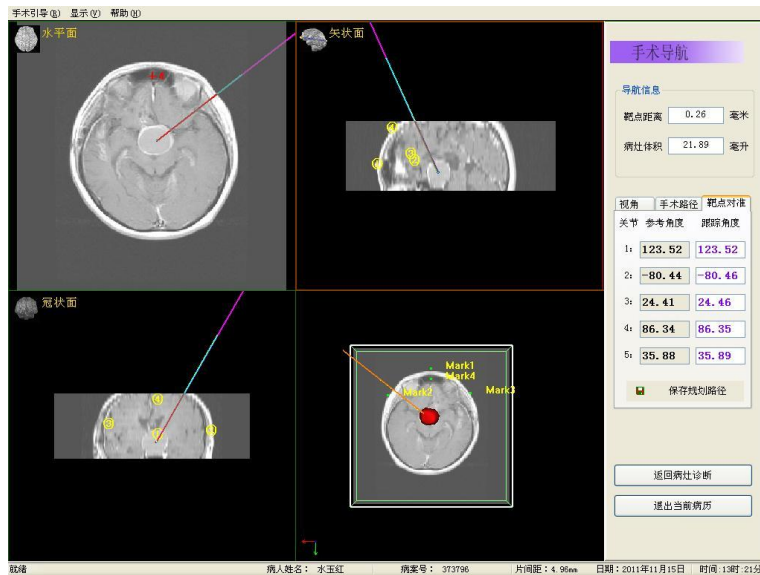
Snapshot picture of the operative interface for frameless stereotactic operation MR images on 3 plane, reconstructed MR images, tumour model and virtual surgical path are shown on the left part; Features of the tumour, real and target position of robot arm are shown on the right part.
